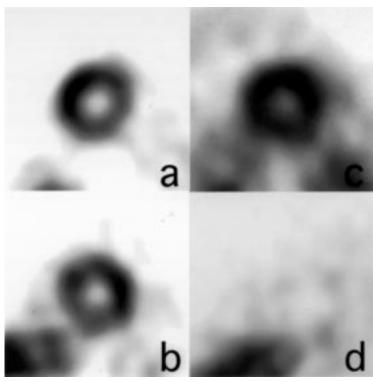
Short axis views of SPECT of ²⁰¹TICl and ¹²³I-MIBG myocardial scintigraphy in a healthy control (a, b) and a 57 year old woman with Parkinson's disease (Hoehn and Yahr stage I) (c, d).
